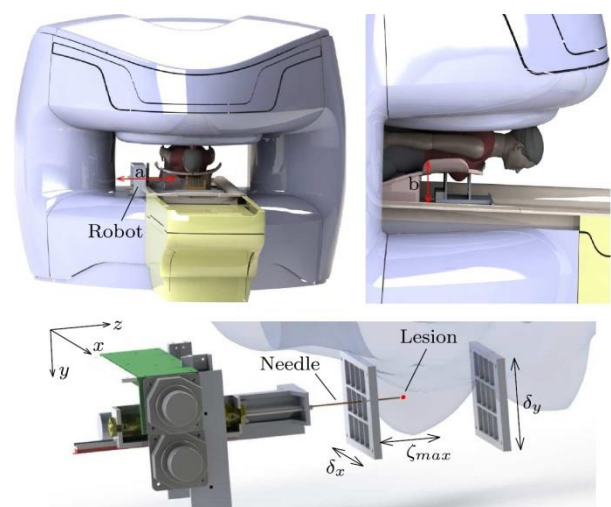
Setup of pneumatically actuated breast biopsy robot in open MRI bore [34].
